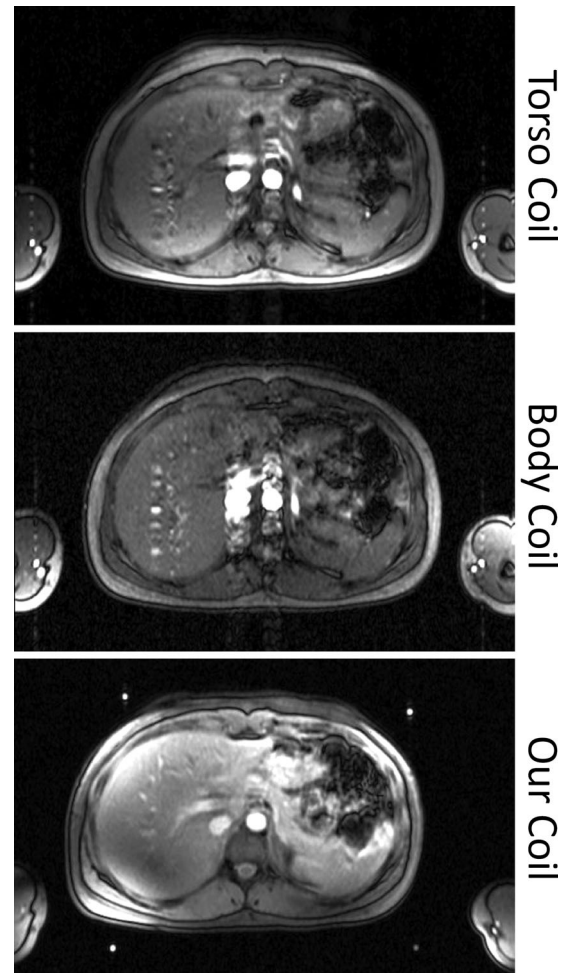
<sup>1</sup>H images obtained from a dedicated torso coil, the scanner's body coil, and our coil using the same acquisition protocol (gradient echo sequence). The four bright spots on each corner of the image obtained with our coil correspond to the water-filled fiduciary markers placed on the coil to ensure reproducible MRSI planning and acquisition. The new coil provides high-quality <sup>1</sup>H MRI images, adequate for most clinical imaging protocols in the liver.
